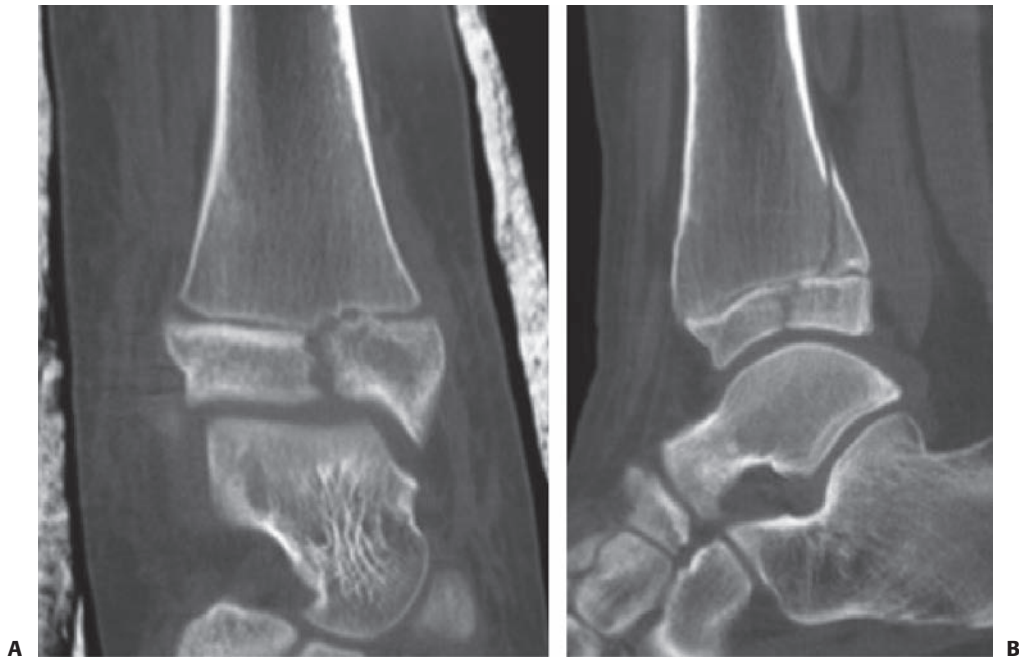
Computed tomography of a triplane fracture of the distal tibia which typically is involving vertical sagittal (epiphyseal), horizontal axial (physeal), and vertical coronal (metaphyseal) components. (Property of UW Pediatric Orthopaedics.)
